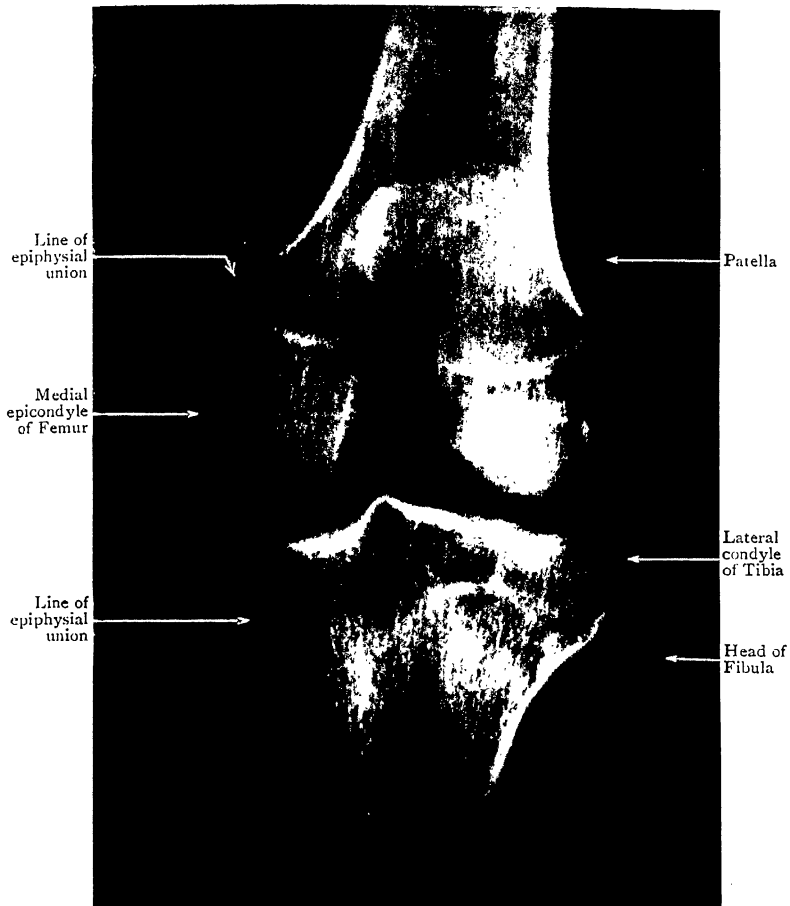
Radiograph of Left Knee of young man aged 22.
